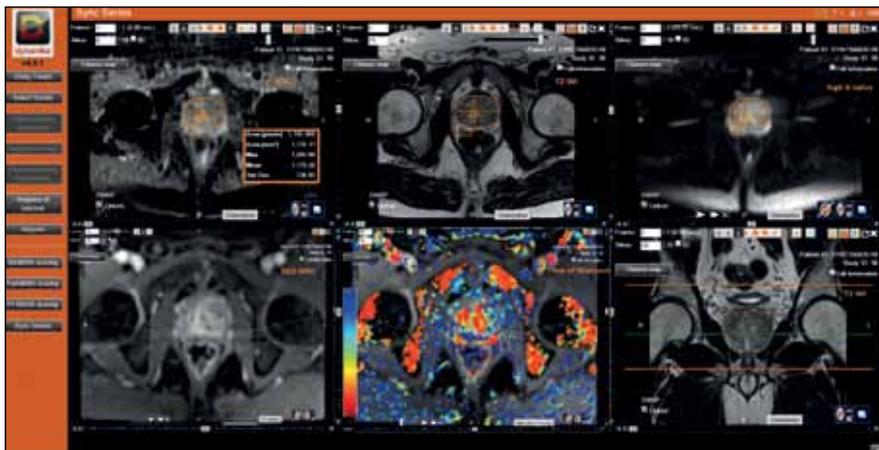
Advanced quantitative mpMRI analysis in Dynamika, from top left to right: 1. apparent diffusion coefficient (ADC) map with statistics for region of interest (ROI) for cellular density 2. axial T2-weighted image for anatomical volume information (ruler, 2D ROI and 3D ROI available) 3. diffusion weighted Image (DWI) of high b-value 4. DCE-MRI perfusion 5. Derived Time of Washout map overlaid on DCE data 6. coronal T2-weighted image for spatial slice localisation.
